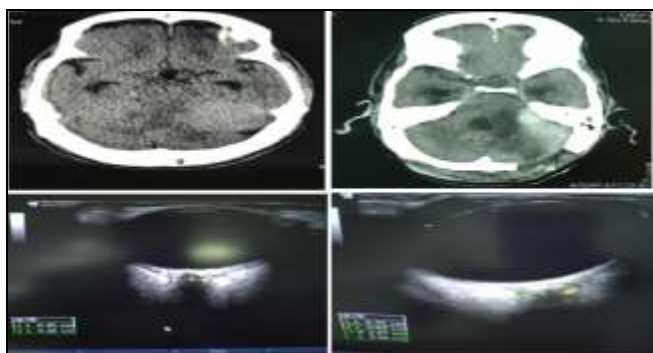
A, B, C, D, USG ONSD and CT scan for Detection of raised ICP in 57 years old male with Meningioma who Developed post Neurosurgery Meningitis Associated with Secondary Hydrocephalus
